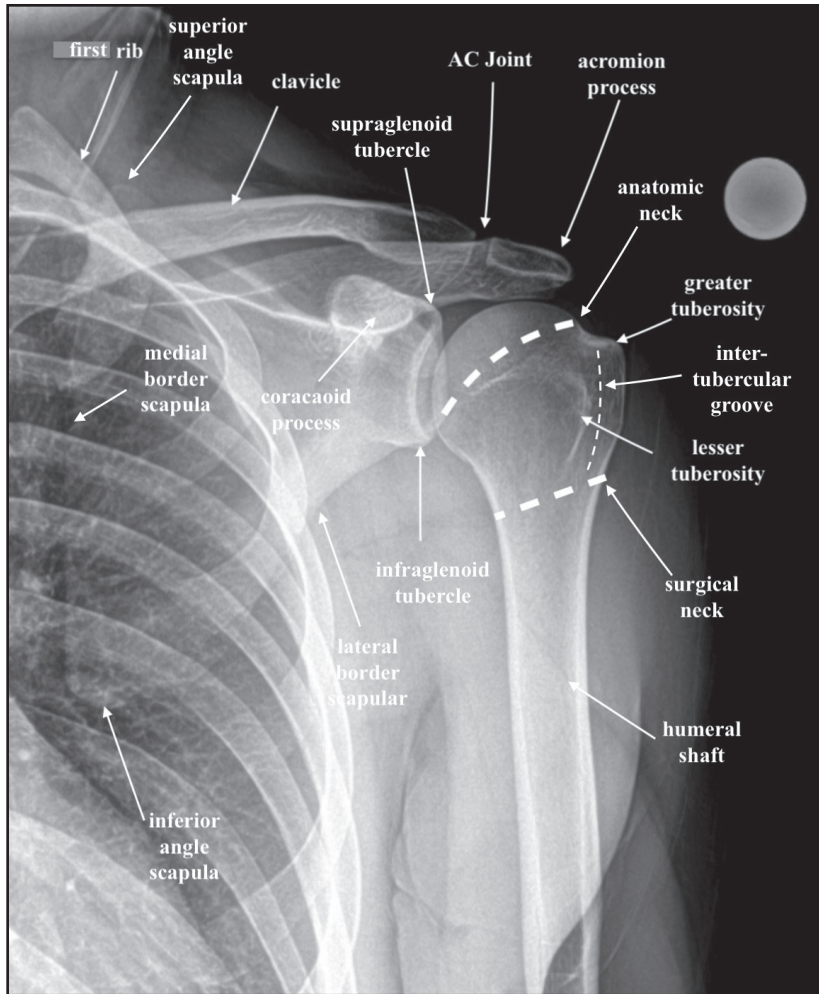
Anterior-to-posterior shoulder radiograph with anatomic landmarks labeled.
